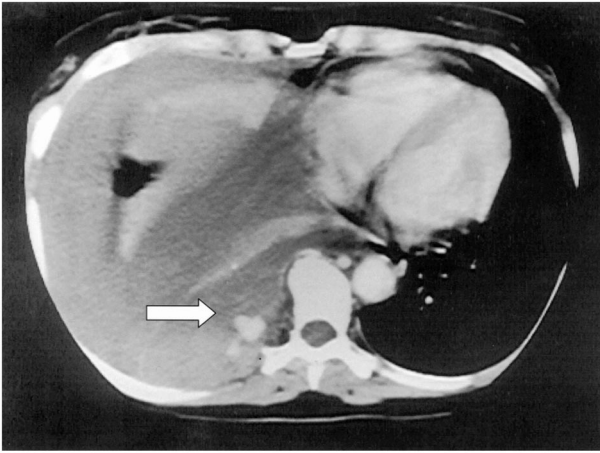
Thoracic CT-scan revealing the spot of contrast medium suggesting an aneurysm.
